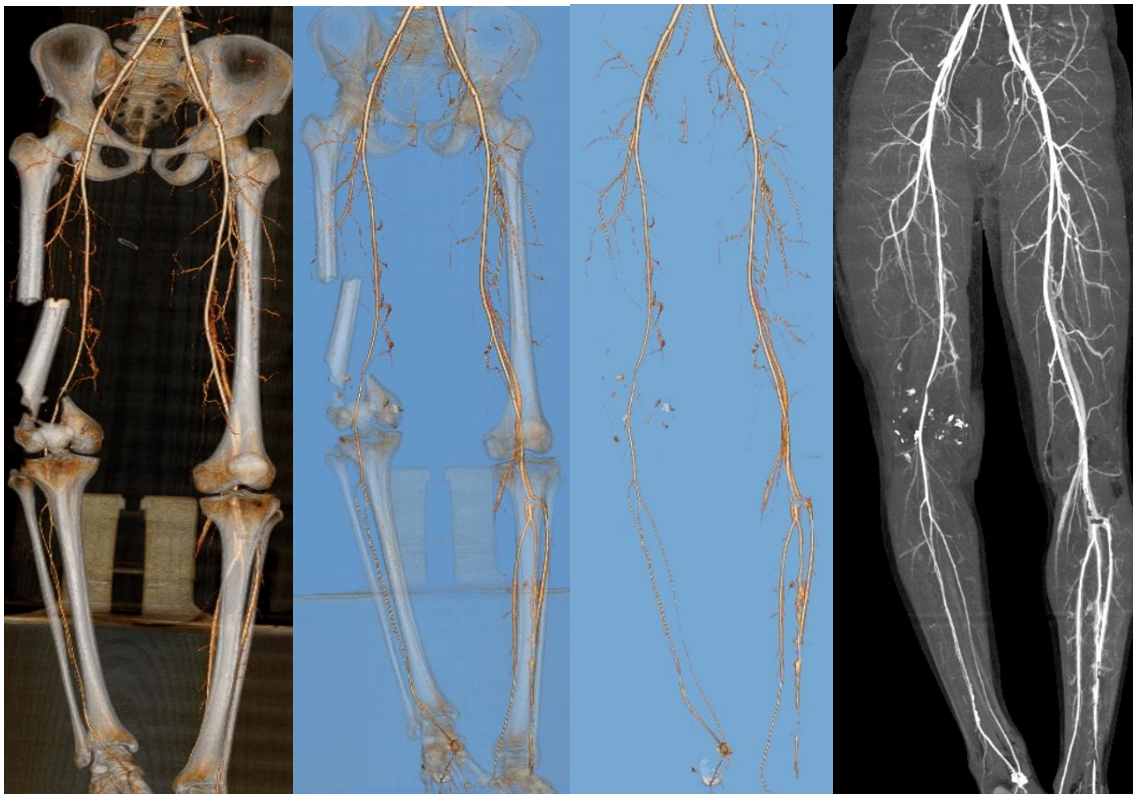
(A-D).3D volume rendered (A-C) and maximum intensity projection (MIP)(D) CTA images reveal comminute fractures of distal half of femur with displacement of fracture fragments, causing focal kinking and external compression of distal one third of superficial femoral artery.
